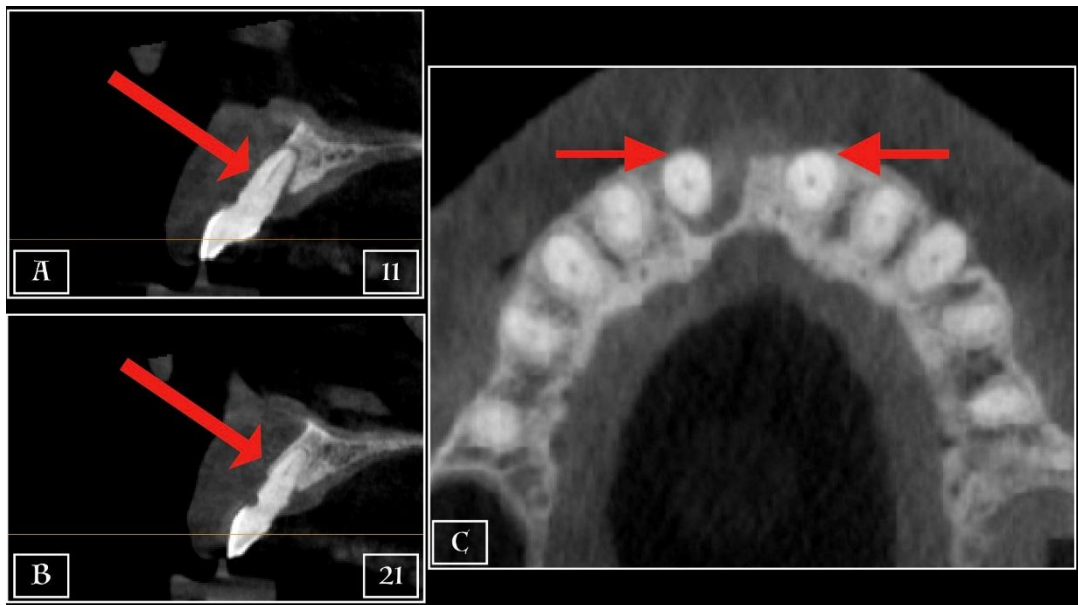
Pre - Operative Cone Beam CBCT scan
